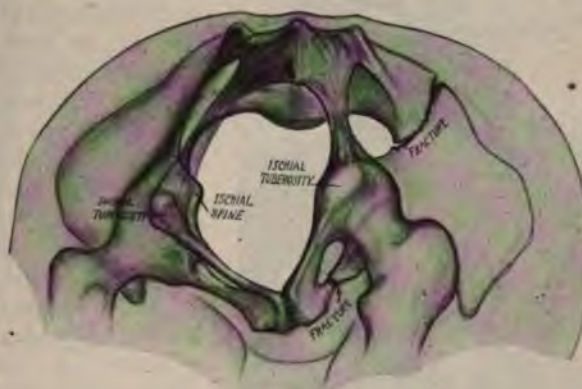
FRACTURE OF THE PELVIS DUE TO A RAILROAD ACCIDENT. ABSOLUTE DEFORMITY PRODUCED. FROM AN X-RAY PICTURE.
